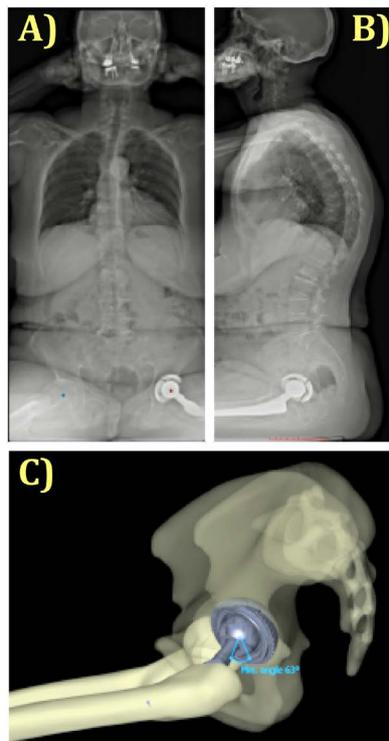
Sitting EOS-radiographs: (A) anterior view; (B) lateral view; (C) lateral view of 3D-reconstruction, no limitation to hip motion.
